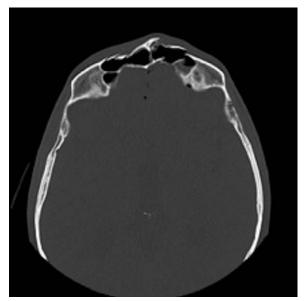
Preoperative axial computed tomography scan of the frontal sinuses.
